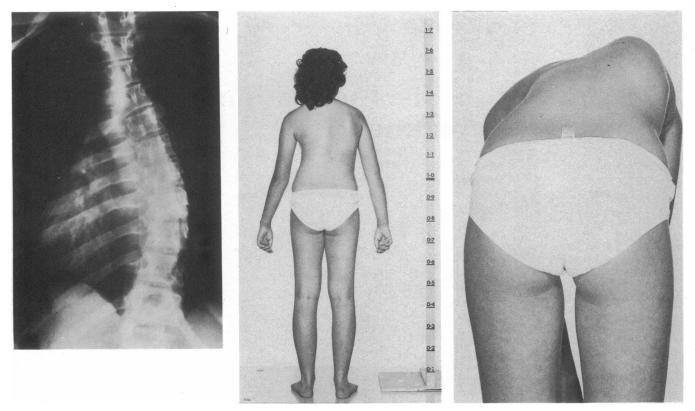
(a) posterior-anterior (PA) X-ray of a patient with idiopathic scoliosis. The posterior elements are rotated into the curve (b) A patient with an idiopathic thoracic scoliosis standing. The deformity must be lordotic throughout.
